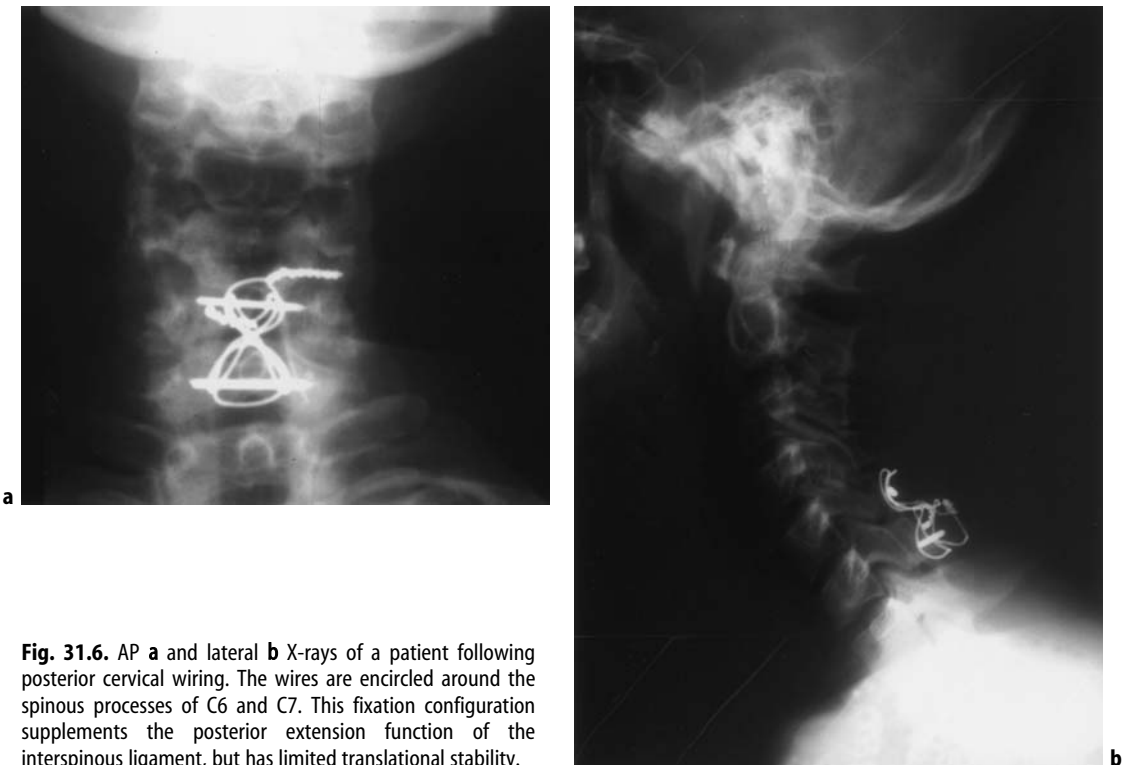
AP a and lateral b X-rays of a patient following posterior cervical wiring. The wires are encircled around the spinous processes of C6 and C7. This fixation configuration supplements the posterior extension function of the interspinous ligament, but has limited translational stability.
